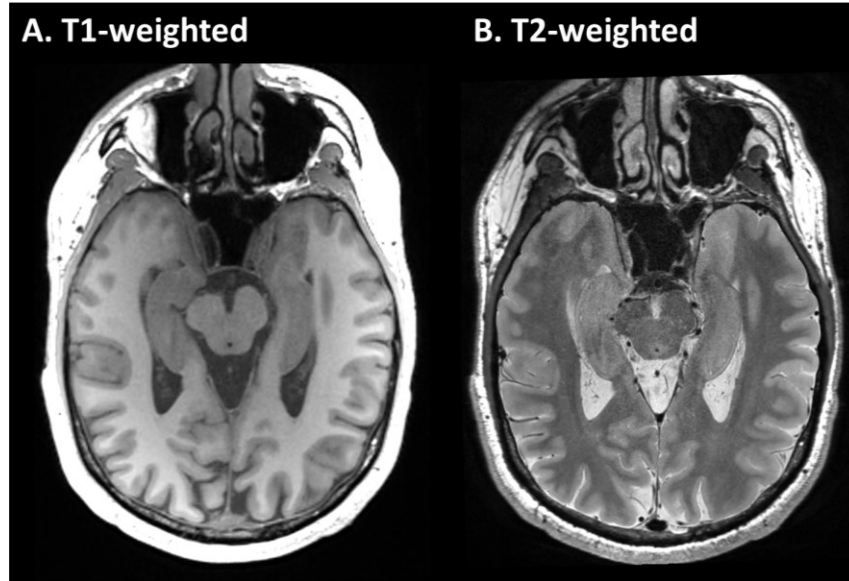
(A) Example of a T1-weighted magnetization prepared rapid acquisition with gradient echo (MPRAGE) image and (B) T2-weighted images. Both images were acquired with 1 mm isotropic resolution. The MPRAGE image was reconstructed along the long axis of the hippocampus to match with the axial hippocampus T2-weighted image.
